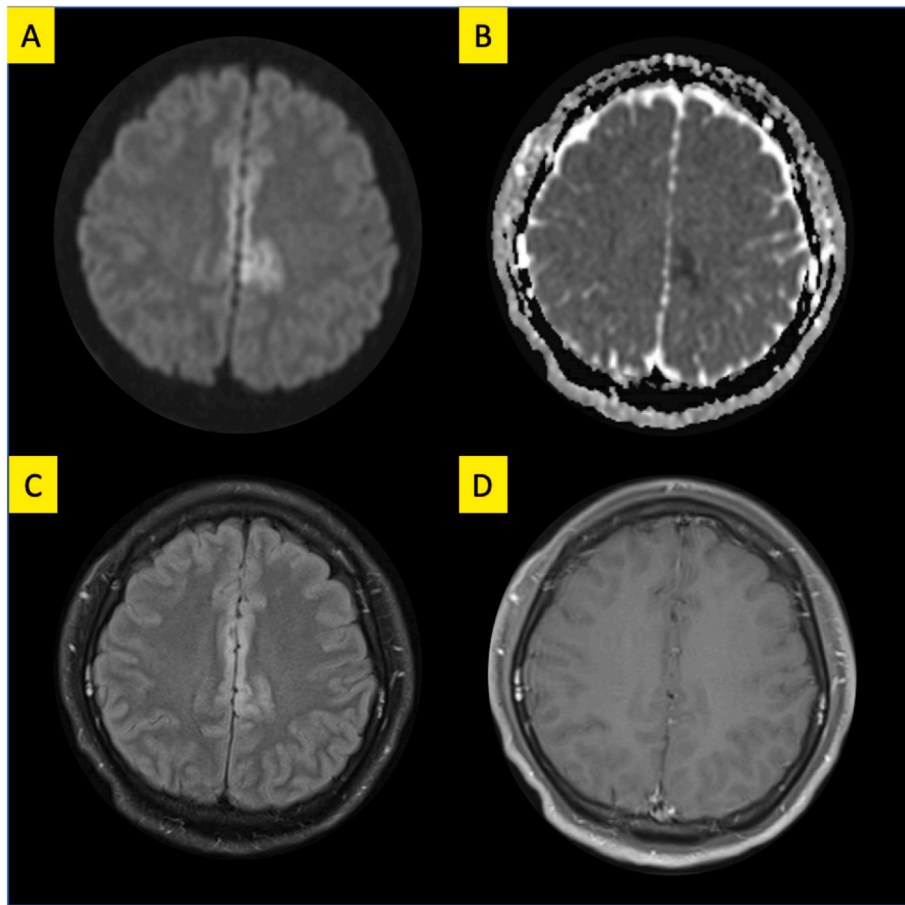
A–D: MRI brain with and without contrast obtained in the Neuro-ICU.
